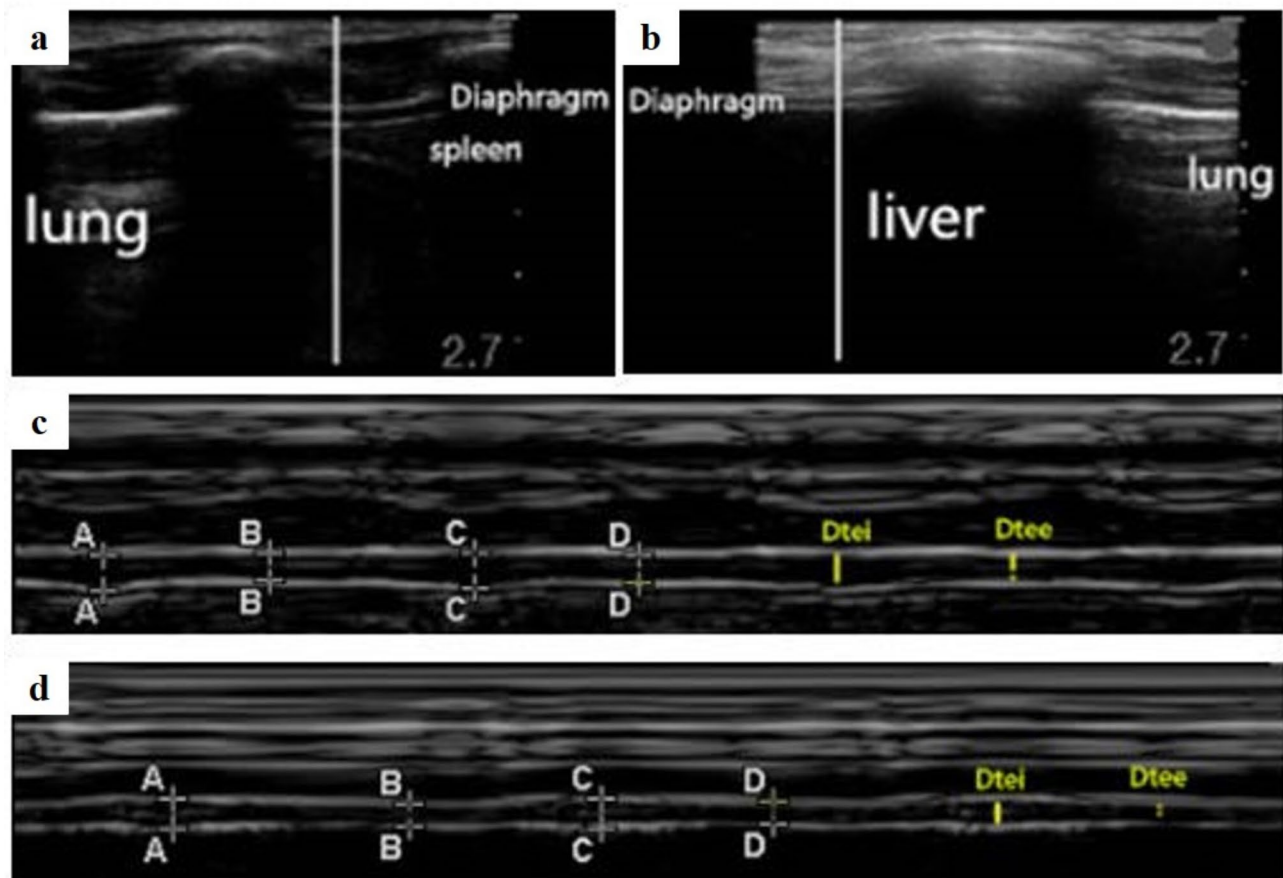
Characterized image of diaphragmatic ultrasound. A-A and C-C represent Dtei: diaphragm thickness at end-inspiration; B-B and D-D represent Dtee: diaphragm thickness at end-expiration
